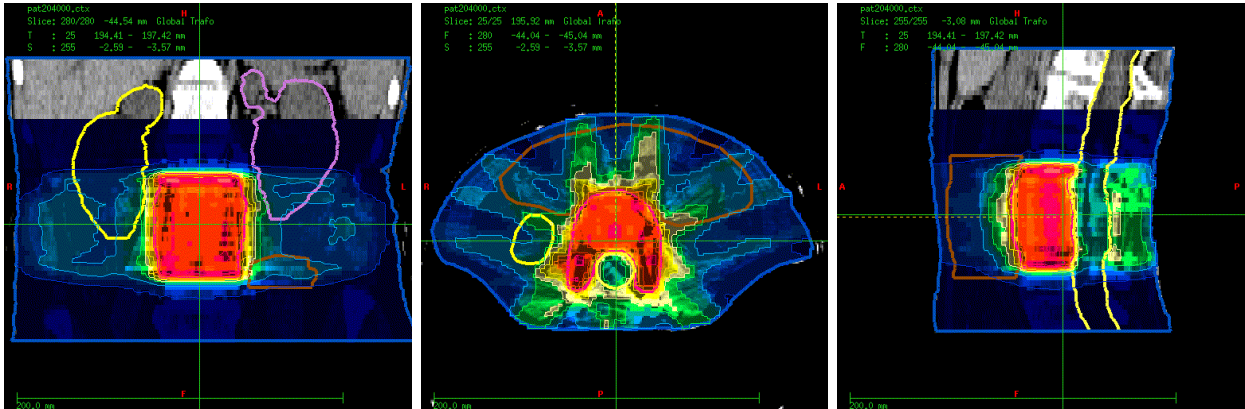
CT images of the abdominal cancer case overlaid with the 0 T dose distribution: frontal, transverse and sagittal plane (from left to right).
